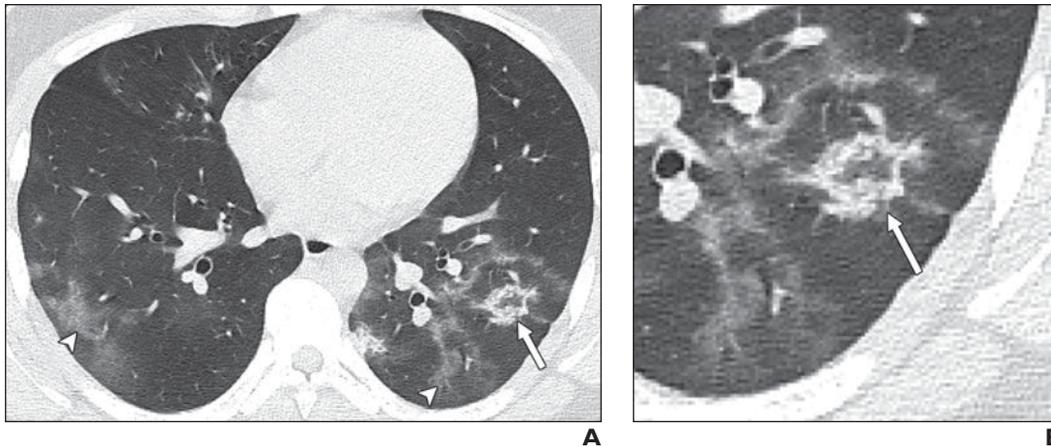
18-year-old boy with coronavirus disease with multilobe involvement. A, Unenhanced chest CT scan shows predominant peripheral and basilar distribution of ground-glass opacities (*arrowheads*) and area of ground-glass opacity in left upper lobe with peripheral consolidation (*arrow*), latter of which is known as reverse halo sign. CT findings were assigned CT severity score of 4. B, Magnified view of unenhanced chest CT scan in A provides clearer view of reverse halo sign (*arrow*) in left lower lobe.
